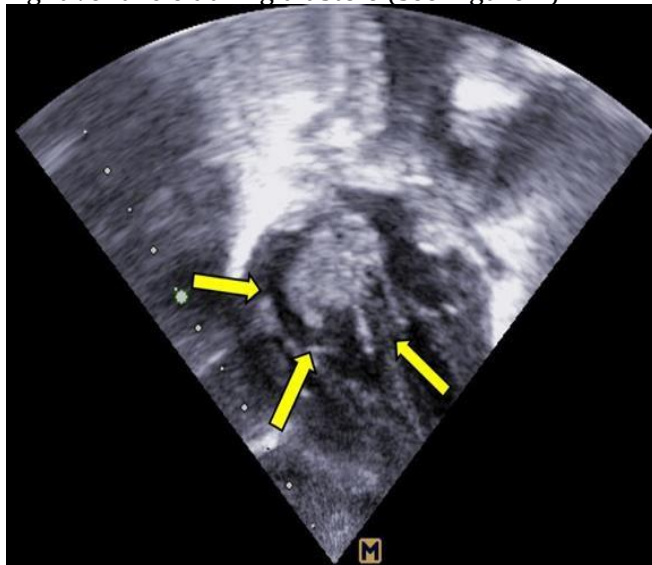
Transthoracic echocardiogram, apical 4-chamber view. The recurrent thrombus is observed descending through the tricuspid valve toward the right ventricle during diastole, with pendulous mobility. This dynamic behavior confirms its high embolic potential and the complexity of clinical management in the neonatal context.
